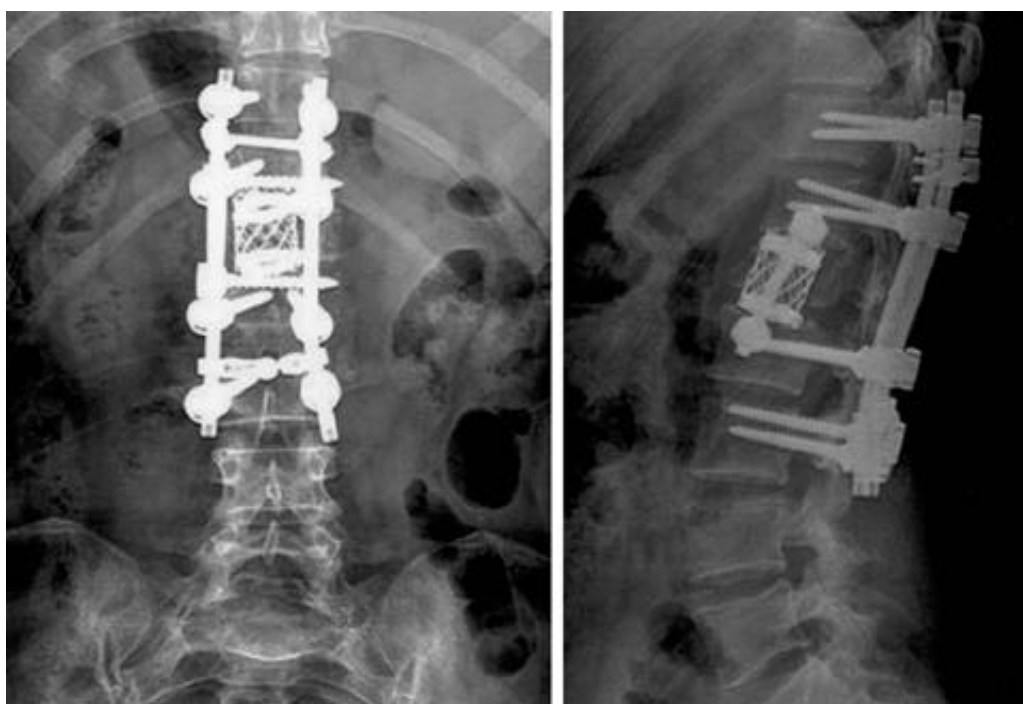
In follow-up radiographs, it shows circumferential fusion of the unstable burst fracture.
